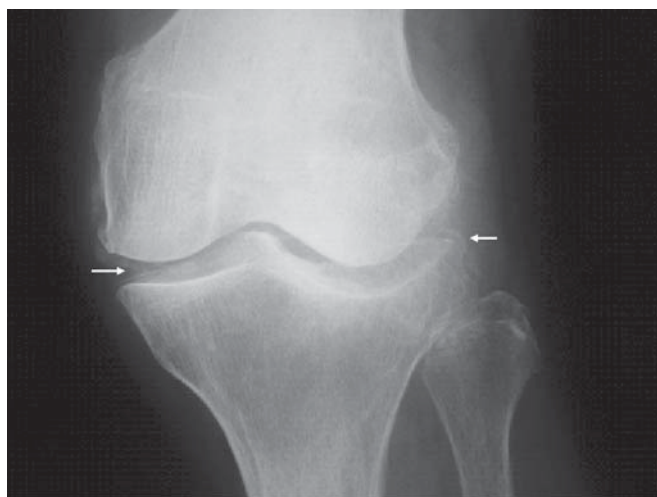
Plain radiography of the left knee shows calcium deposition on the meniscus (*arrows*) and bone destruction of the lateral compartment. Involvement of the lateral compartment of the knee, which is rarely seen in ordinary degenerative osteoarthritis, represents a distinctive feature of calcium pyrophosphate dehydrate (CPPD) arthropathy
